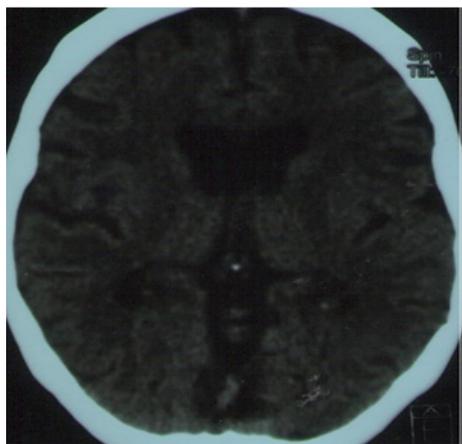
Head (CT) Scanning: An Apparent Atrophy at the Right Perisylvian Area in Younger Women With Visual Hallucination
